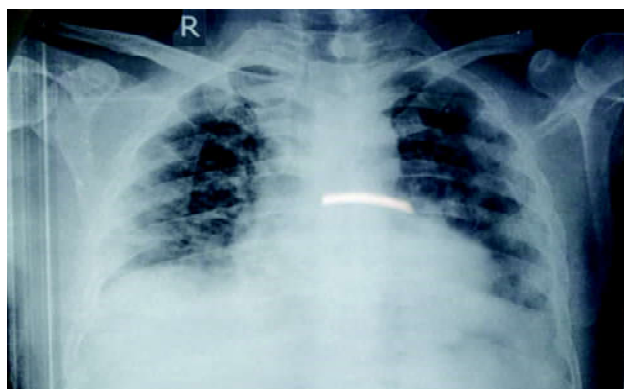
Chest X-ray showing bilateral peripheral opacities with clearing compared to previous X-ray (Case 5, after plasma therapy).
